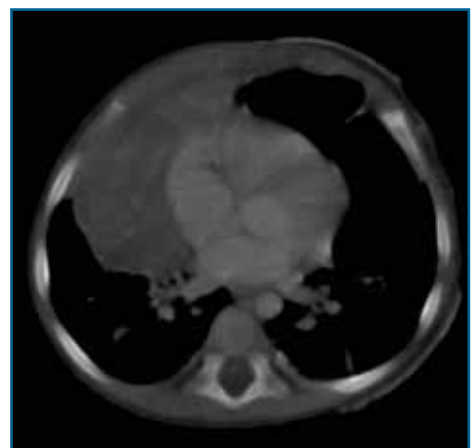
CT scan of the chest showing an anterior mediastinal mass
